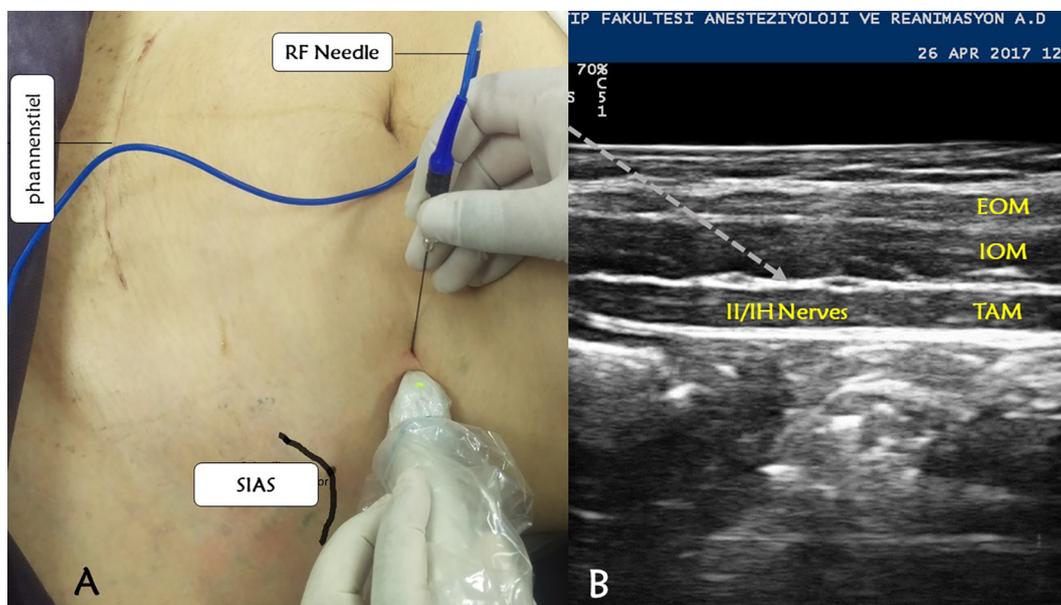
A. Needle and transducer position for II/IH nerve PRF, B. Sonographic anatomy of the II/IH nerves. II/IH: Iliioinguinal/Iliohypogastric, PRF: Pulsed radiofrequency. RF: radiofrequency. ASIS: anterior superior iliac spine. EOM: External oblique muscle, IOM: Internal oblique muscle, TAM: Transversus abdominis muscle. The grey arrow indicates the needle.
